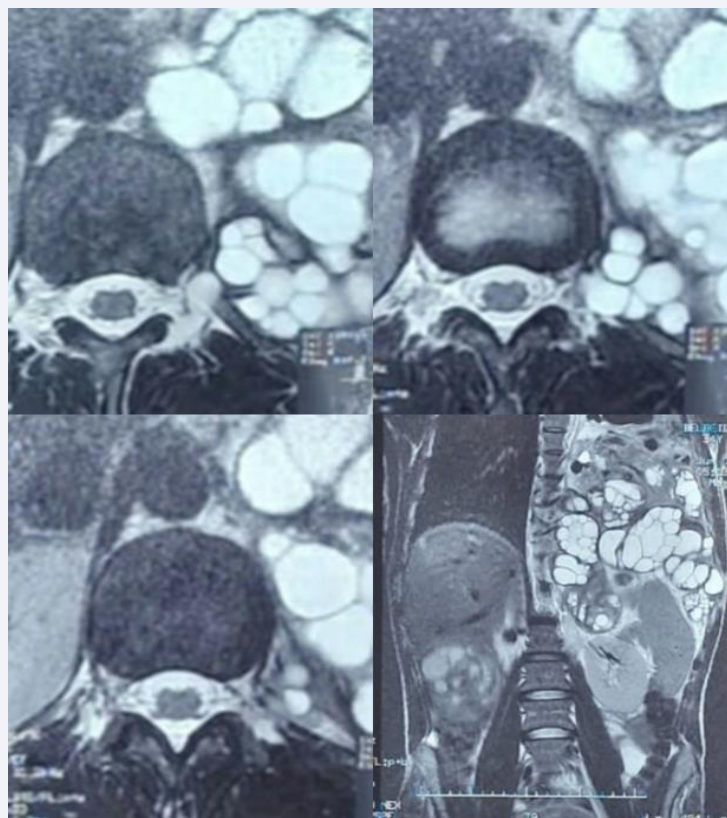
Spinal MRI: Cystic lesion of the conjugate foramina of D11 and D12 vertebral bodies without intra canal extension.
